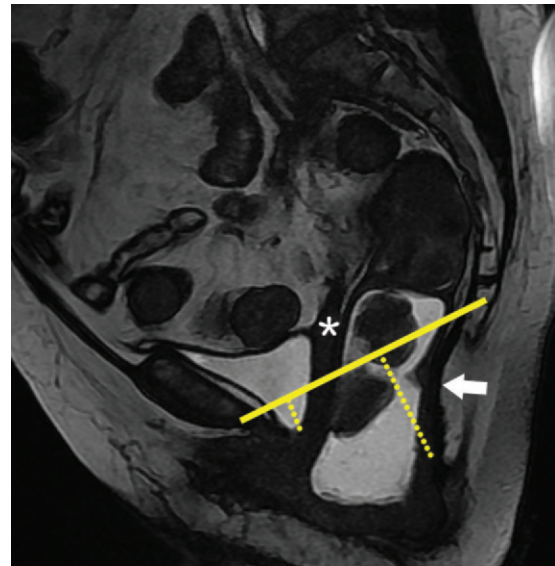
Peritoneocele in a 60-year-old woman who had a history of surgical treatment for urinary incontinence. Sagittal FIESTA MR image obtained at maximal effort during defecation shows herniation of a small amount of mesenteric fat into the rectovaginal space (arrowhead). In the anterior and middle compartments, a mild cystocele (left dotted line) and mild uterine prolapse (right dotted line) are seen in relation to the PCL (solid yellow line). Intrarectal intussusception (*) is seen in the posterior compartment. Note the caudal angulation of the levator plate (arrow) and descent of the anorectal junction. The recognition of a peritoneocele is important because it predisposes to enterocele formation and suggests the need for surgical closure of the cul-de-sac if reconstructive surgery of the pelvic floor is undertaken.
